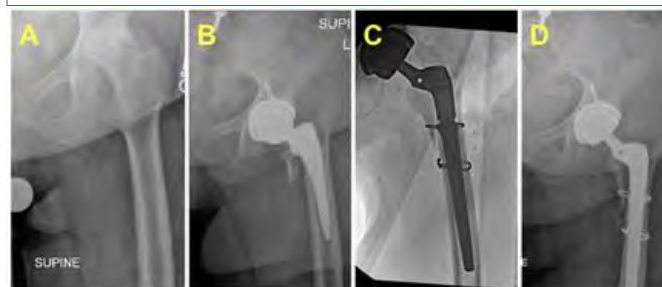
Preoperative (A) and postoperative (B) radiographs demonstrating a periprosthetic Vancouver B2 fracture. The patient began feeling pain overnight on postoperative day 15. They reported to the emergency department, and a fracture was found. Stem was revised, and two cables were placed (C). New stem stable 4 weeks postoperative (D).
